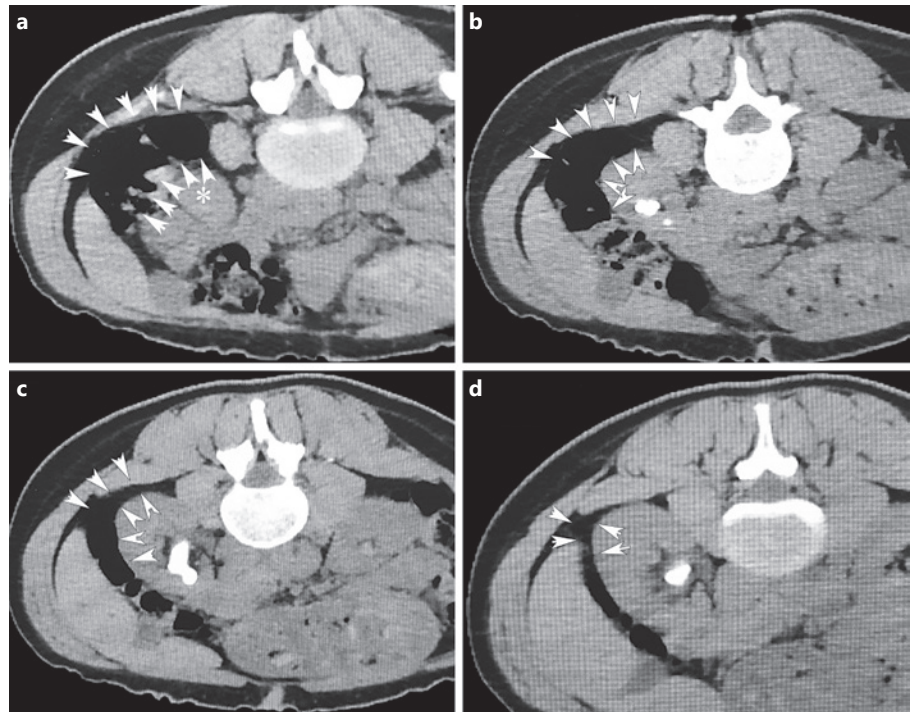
Computed tomography images of a patient with severe RRC. a * Lower pole of the left kidney, arrow heads indicate the colon. b–d Arrow heads indicate the RRC. RRC, retro-renal colon.
